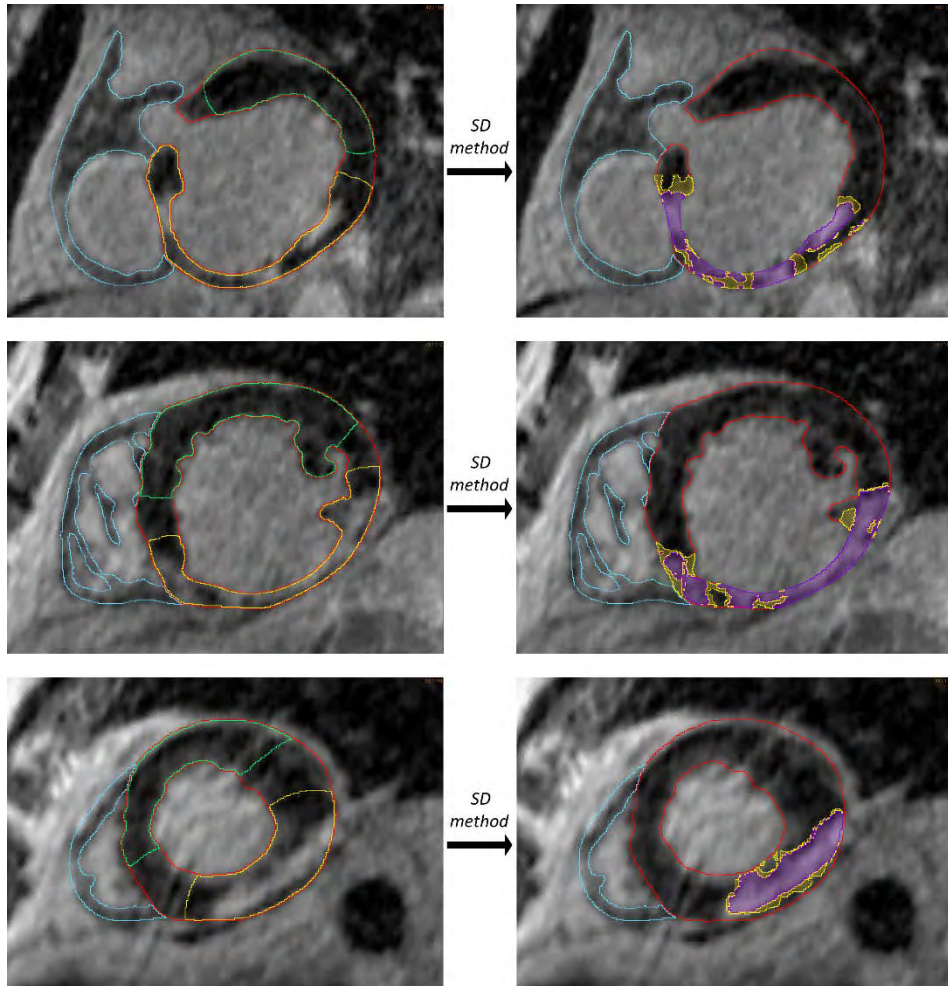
Segmentation process from DE-MRI slices of the heterogeneous remodelling related to the MI, including infarct scar and BZ. Each row shows examples of the two steps of segmentation process on short-axis DE-MRI slices at basal (*top*), mid-ventricular (*middle*) and apical (*bottom*) level of ventricles. *Left column* shows the first step that involves the manual definition of remote (*green*) and infarcted ROIs (*yellow*) within the LV myocardium ROI (*red*), also displaying the RV myocardium ROI (*cyan*). *Right column* shows the segmentation ROIs for infarct scar (*purple*) and BZ (*yellow*) resulting from the application, within the infarcted ROI, of the thresholds determined by SD method from the remote ROI of each slice.
